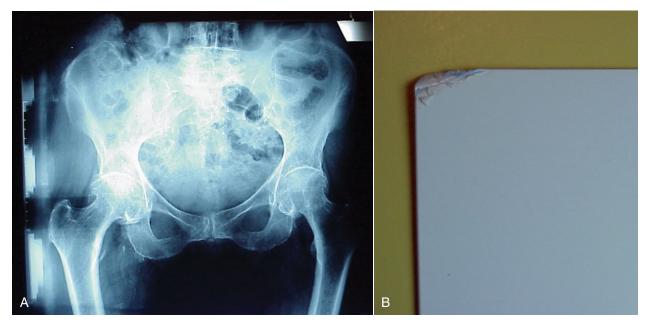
A, Note the white shapes on the left side, which resulted when the computed radiography (CR) imaging plate came apart. B, This is the CR plate, which shows corner damage and peeling. (Courtesy Barbara Smith Pruner, Portland Community College.)
